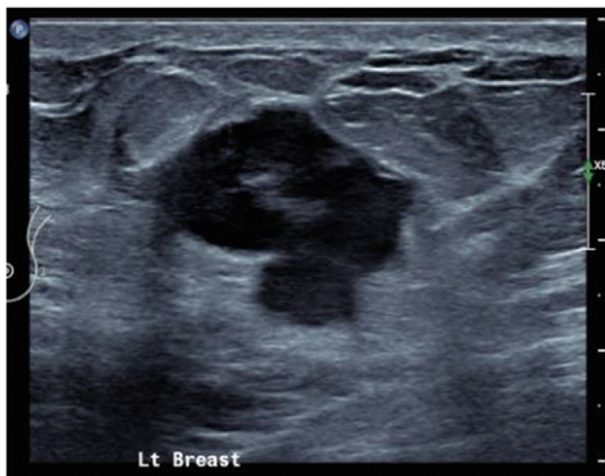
24 mm lesion in the left breast as seen on ultrasound.
